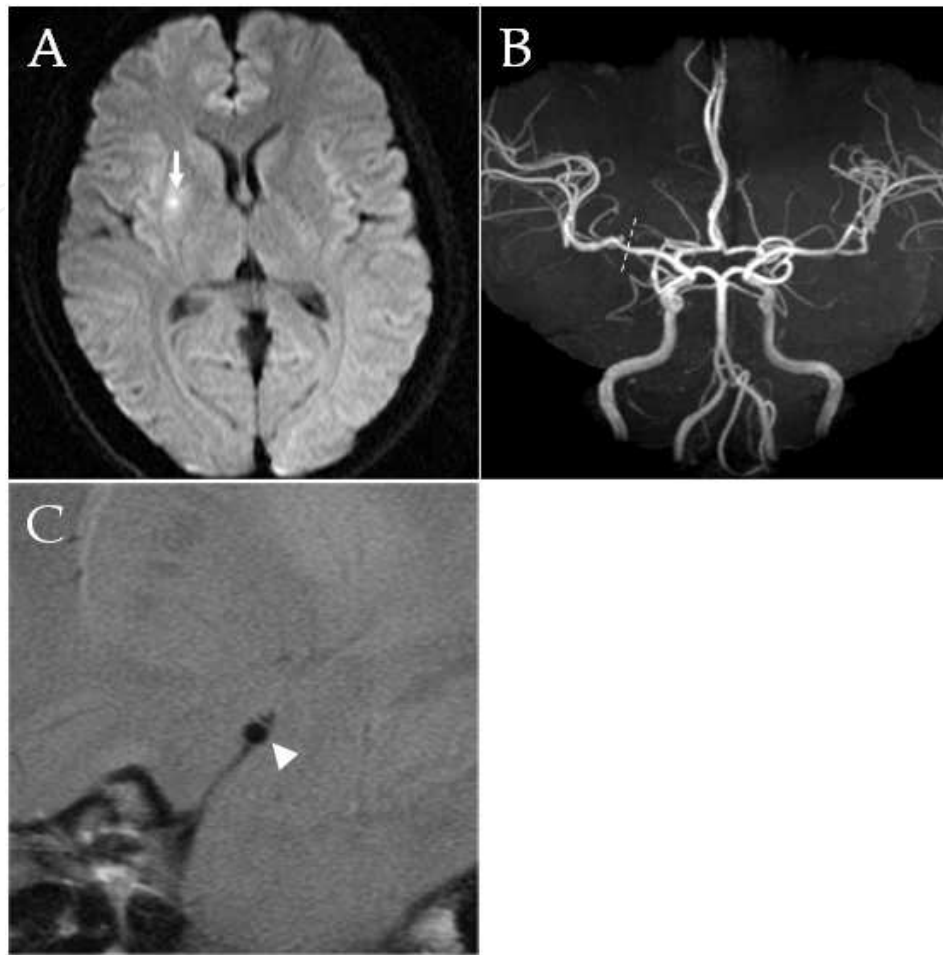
No detection of middle cerebral artery plaque on the right lacunar infarction (modified from Niizuma et al., 2008). Axial Diffusion-weighted image demonstrating a high-intensity lesion in the right putamen (arrow) and corona radiata. B: Magnetic resonance angiography showing no evidence of atherosclerosis. C: High-resolution magnetic resonance image perpendicular to the right middle cerebral artery, at the level of the dotted line in B (TR/TE 2800/50.8, FOV 12 cm \times 12 cm, matrix size 512 \times 256, slice thickness 2 mm, interslice gap 0.3 mm, NEX 5), presenting the lumen of the middle cerebral artery (arrowhead), though there were no plaques on the vessel wall.
